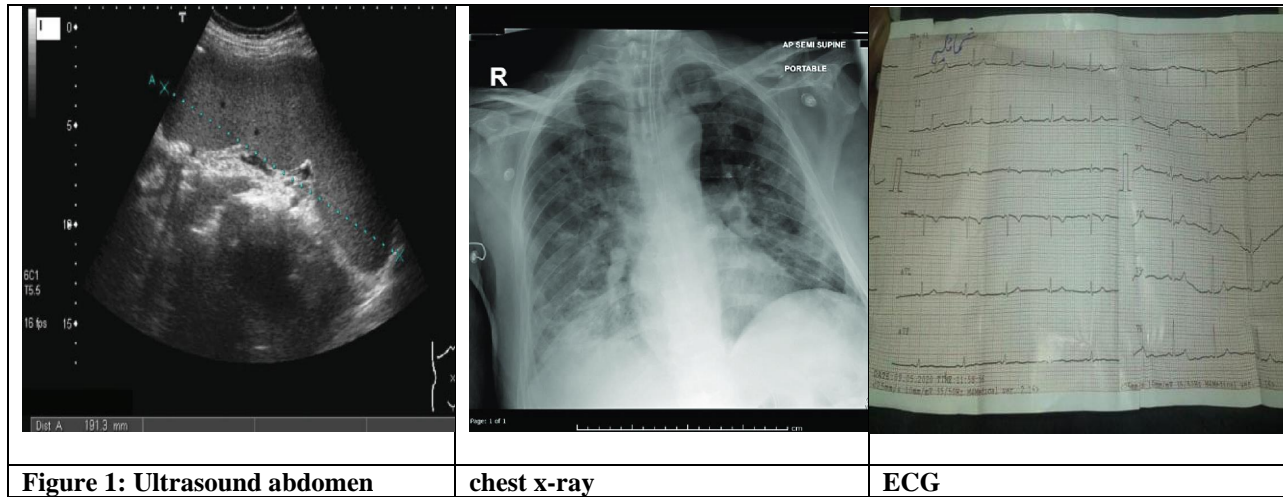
Ultrasound abdomen
